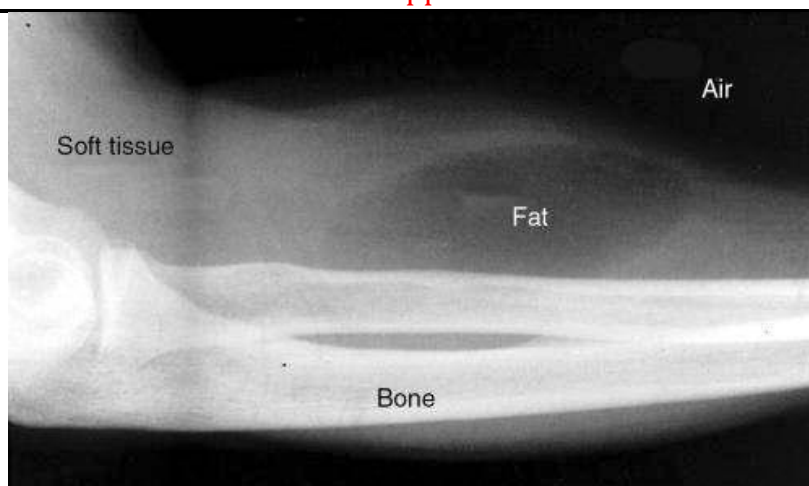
The four basic densities on an x-ray. The abnormality in this case is the fat in the soft tissue of the forearm, which is due to a lipoma.
